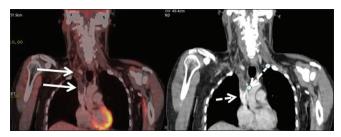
Coronal fluorine-18 fluorodeoxyglucose positron emission tomography/ computed tomography postradiotherapy showing complete metabolic regression in the intravascular tumor (arrow) with significant reduction in the tumor thrombus load and better contrast passage through the superior vena cava (dotted arrow)
